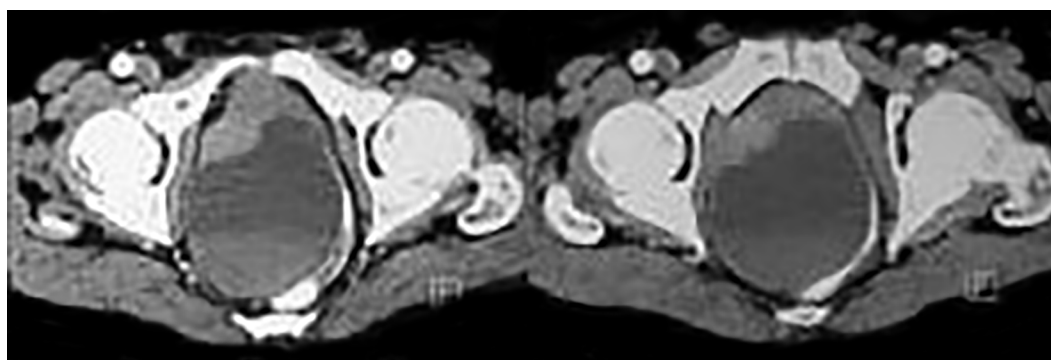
Contrast-enhanced computed tomography showing large cystic lesion
